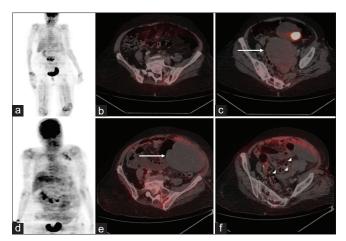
Maximal intensity projection (MIP) (a) of baseline fluorodeoxyglucose positron emission tomography/computed tomography scan. Axial fused (b and c) images showing nonfluorodeoxyglucose-avid mass in the pelvis (fibroid) and no mass in the abdominal region. MIP (d) of follow-up fluorodeoxyglucose positron emission tomography/computed tomography scan. Axial fused (e and f) images showing nonfluorodeoxyglucose-avid mass lesion in the abdominal and pelvic region, connected to the uterus with a pedicle (arrowhead). The comparison reveals that the previously noted mass involving the anterior wall of the uterus was not visualized on the present scan with evidence of nonfluorodeoxyglucose-avid mass in the abdominal and pelvic region.
